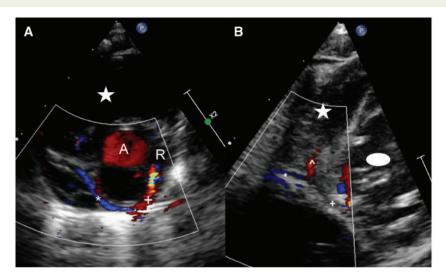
Left circumflex artery arising from right coronary artery. (A) Short-axis view and (B) apical four-chamber view posteriorly. *, right coronary artery; +, left circumflex coronary artery, Λ , posterior coronary collateral; \bigstar , right ventricle; \bullet , left ventricle; A, aorta; R, right pulmonary artery.
